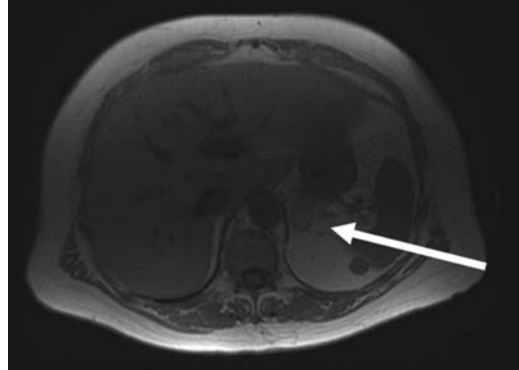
T1 MRI with characteristic hyperintensity of a myelolipoma.
